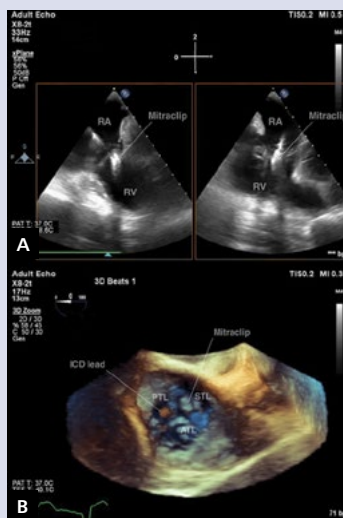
A. Transoesophageal echocardiography (TEE), bi-plane, low oesophageal view. MitraClip on septal and anterior tricuspid valve (TV) leaflets; B. TV in three-dimensional TEE, low oesophageal en-face view. MitraClip released from the delivery system on septal and anterior TV leaflets; ICD — implantable cardioverter defibrillator; RA — right atrium; RV — right ventricle
